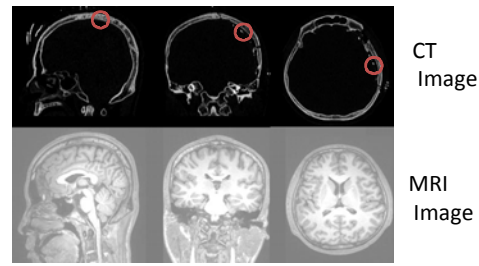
The post-operative CT and the pre-operative MRI scans, with red circles indicating the implanted electrode.
